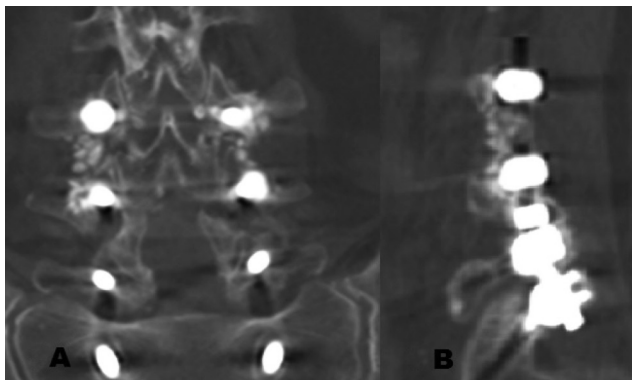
The unexpected fusion (pseudoarthrosis) at coronal (A) and sagittal (B) 3D lumbar computed tomography view after 12 months later surgery
